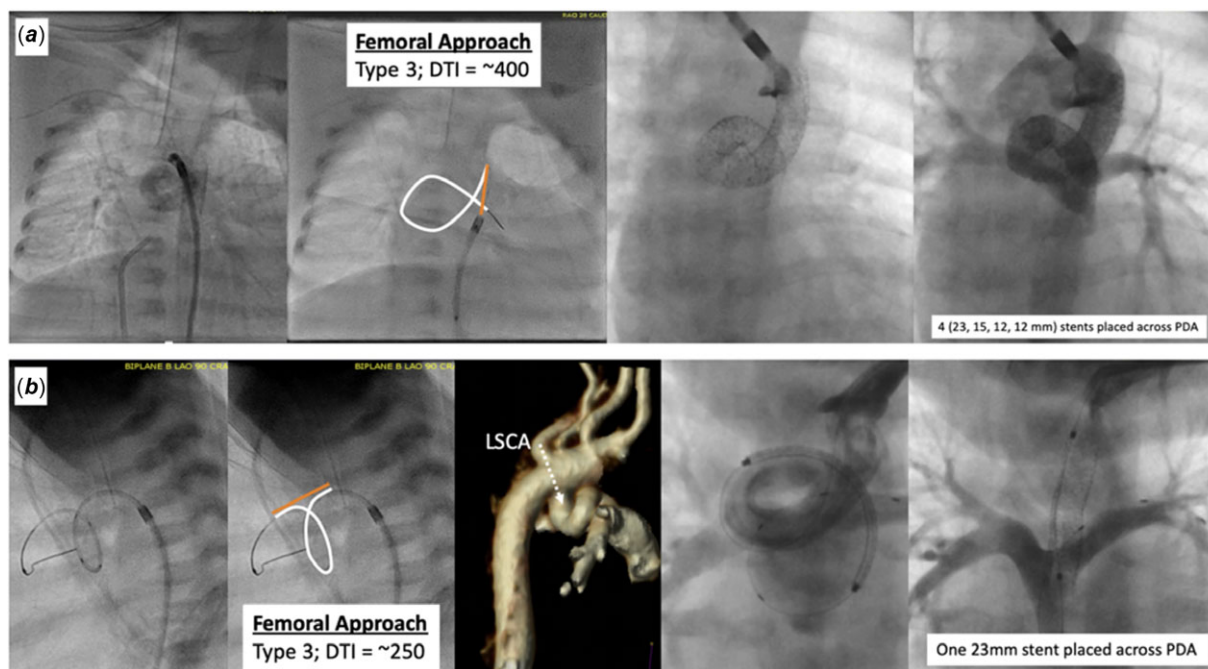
Series of images showing difficulties when stenting a tortuous PDA that does not straighten after traversing with a wire/stent. (a) Upper panel starts with a hand injection at the aortic end of the PDA from the femoral approach showing a type 3 PDA with a ductal tortuosity index (DTI) of approximately 400. The wire and stent would not advance from the femoral approach so a right carotid artery approach was attempted. Notice that the PDA did not straighten out and multiple stents (3.5 mm × 23, 14, 12, 12 mm Vision Multilink stents) were required to traverse the full length of the tortuous PDA. (b) Lower panel shows another example of a tortuous PDA unsuccessfully approached from the femoral artery (type 3; DTI ~250). In this example, the patient was re-approached via the left axillary artery to the left subclavian artery (LSCA) and the PDA straightened out with wire and stent across. This delivery was made much simpler because of the straightening of the PDA with only one long stent required (3.5 mm × 23 mm Vision Multilink). Orange line = Straight PDA length; White (solid) line = Actual PDA length; White (dashed) line = Ideal site of access for PDA stenting virtually represented on CT 3D reconstruction.
